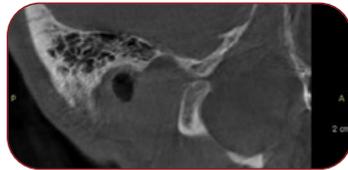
b. CBCT oblique sagittal section of the right TMJ with open mouth (A-anterior, P-posterior). The condyle slides until the anterior tubercle of the temporal bone.
